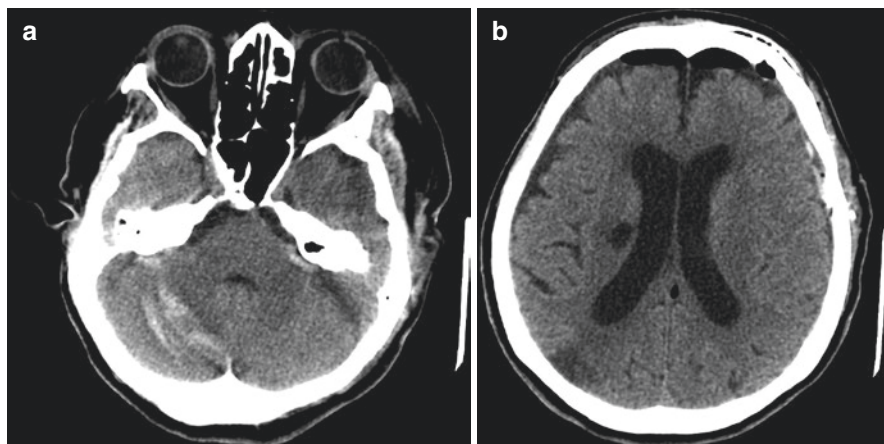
Remote cerebellar hemorrhage in a 55-year-old man 1 day after a left pterional craniotomy for clipping of an aneurysm. Axial CT image (a) shows curvilinear streaks of acute hemorrhage (arrows) in the folia and sulci of the right cerebellar hemisphere. Axial CT image (b) shows a frontal pneumocephalus, an extradural hematoma just below the bone flap, also characterized an acute infarct of the right posterior cortical border zone
